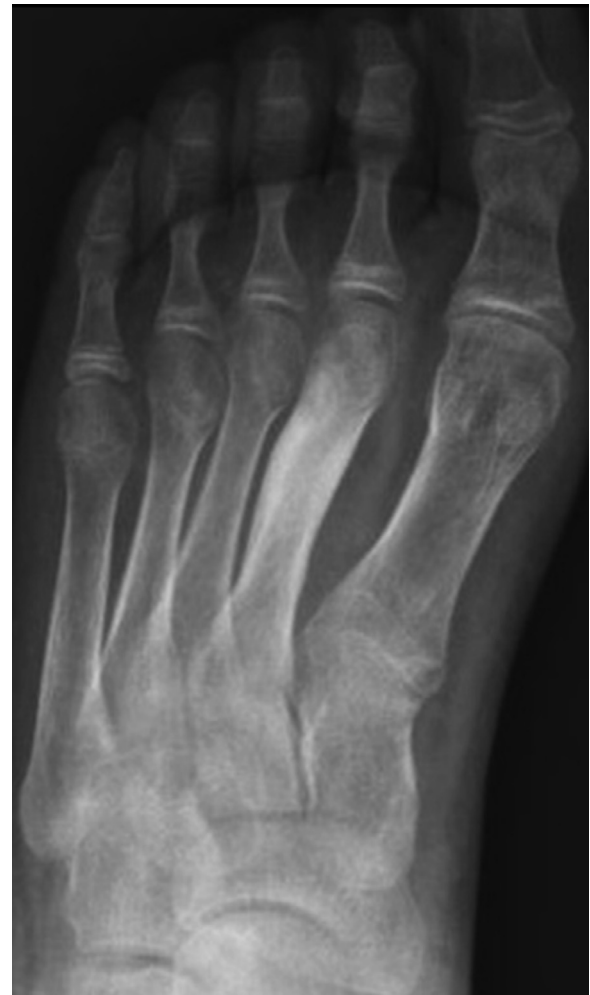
Plain radiograph of the left foot of a 14-year-old boy showing cortical thickening of the second metatarsal bone. The patient was finally diagnosed with osteoid osteoma of the distal part of the second metatarsal bone
